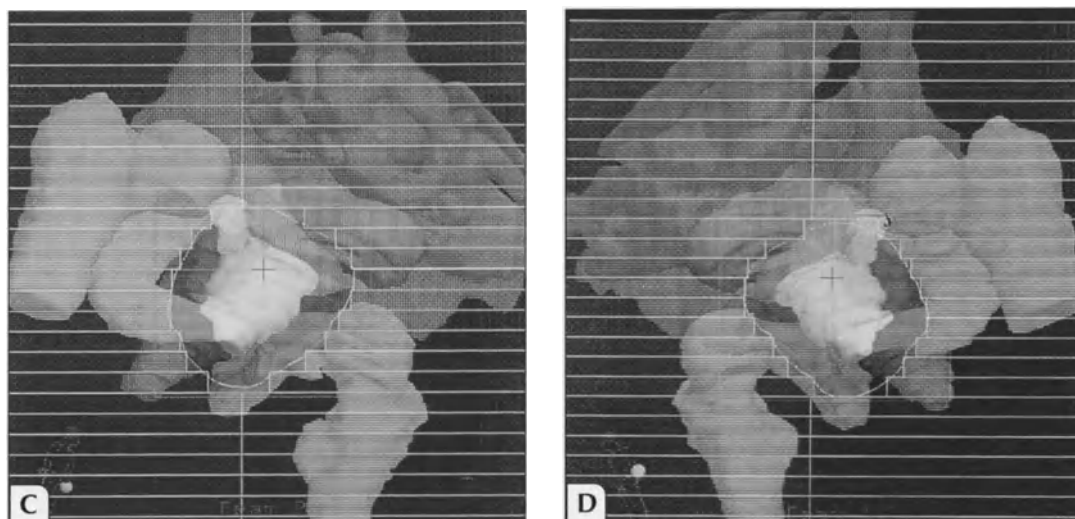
Three-dimensional (3D) treatment planning of external beam radiotherapy for prostate cancer. Current studies have shown that CT-based 3D treatment planning can reduce the acute and late
